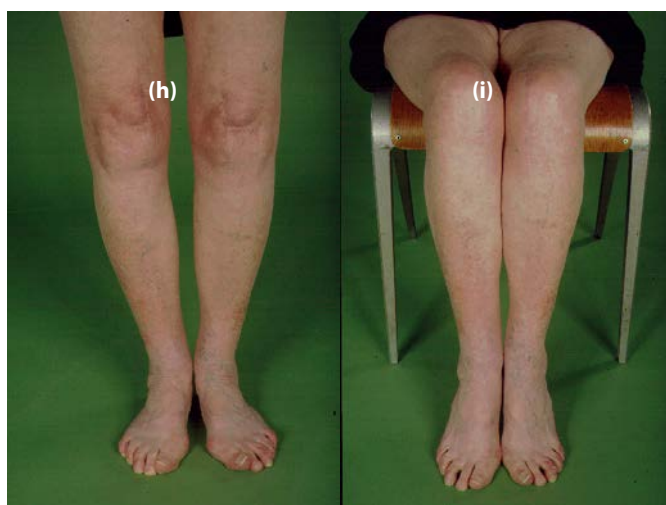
(e) –(i) Because the varus corrected every time the knees were flexed, structural shortening of the medial collateral ligament could not occur. Therefore, with the knees flexed a little, the patient could correct the varus with her own muscles (e). On the radiographs (f), the varus is corrected by applied valgus force. The intraoperative picture (g) shows the anatomical features of anteromedial OA. Note the intact ACL.
